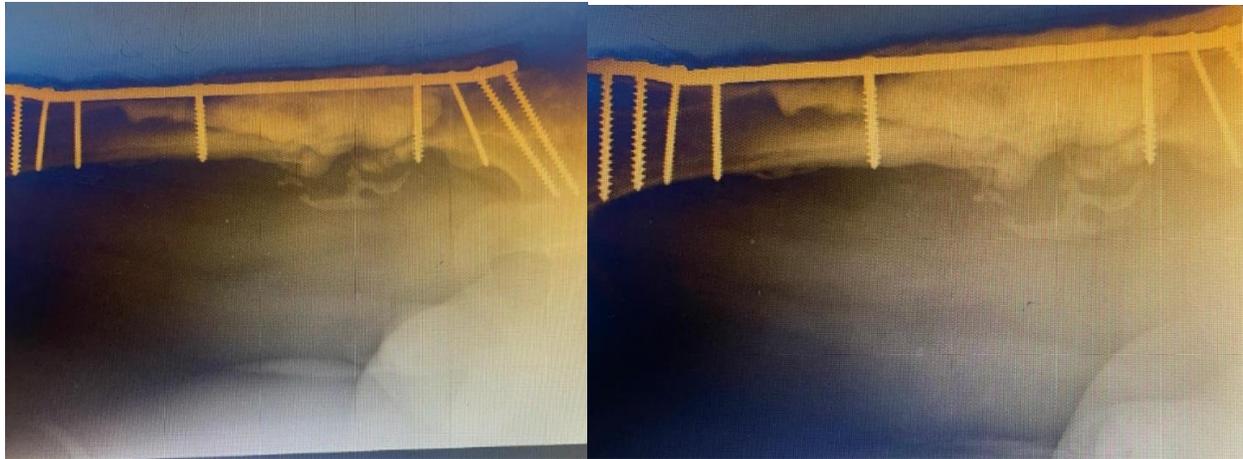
X-ray showed the open reduction internal fixation (ORIF) by plates and screws and application of bone cement mixed vancomycin.
